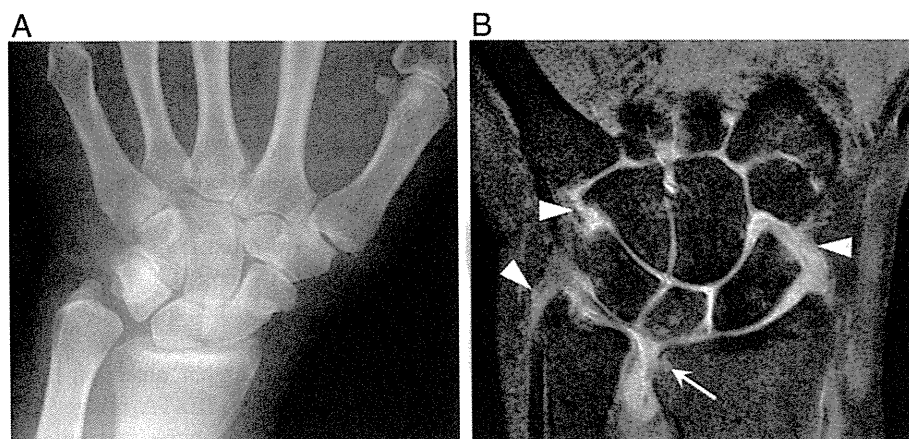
Early rheumatoid arthritis in a 68-year-old woman. Posteroanterior radiograph of the left hand (A) shows no evidence of rheumatoid arthritis. Fat-suppressed intermediate-weighted FSE image (B) shows a diffuse thickening of the synovium (arrowheads) and a bone erosion (arrow).
